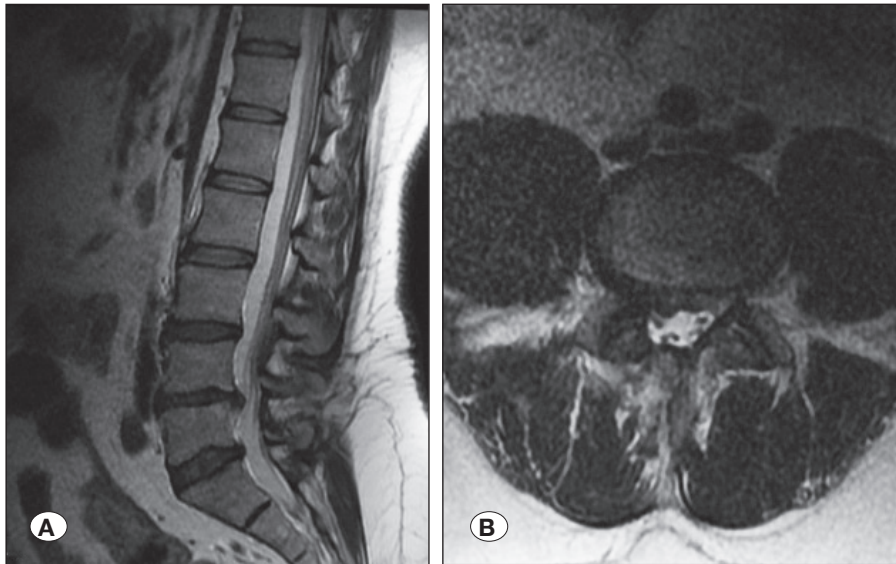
Late recurrent lumbar disc herniation: A) sagittal and B) axial MRI scans of L4-L5 recurrent disc herniation.
